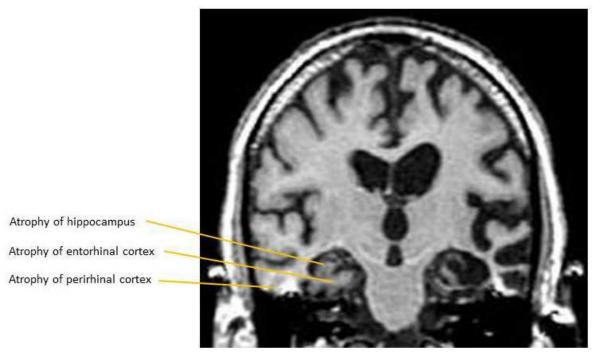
LOAD Endophenotypes on MRI
